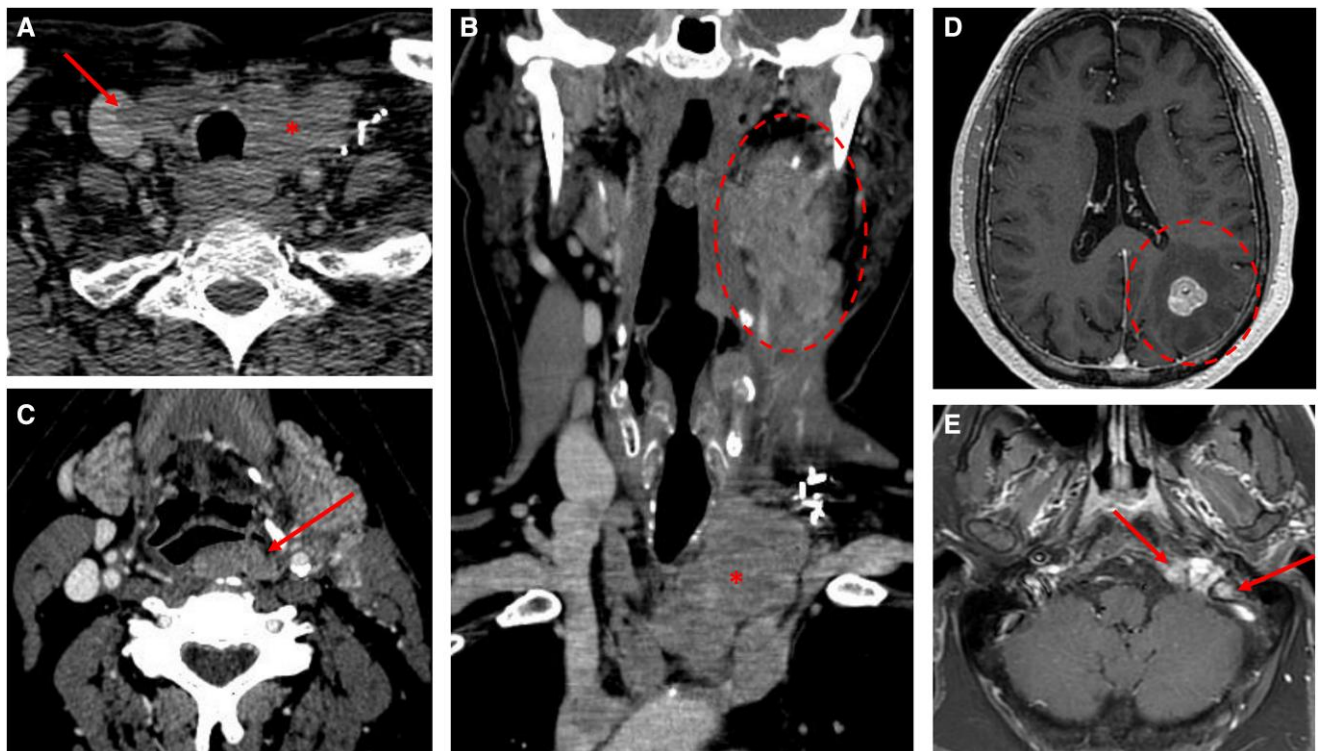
Contrast-enhanced A and C, axial and B, coronal computed tomography images of the neck at initial presentation to our institution (July 2021) demonstrating a lobular 3.4×6 cm mass in the left thyroid bed, extending inferiorly into the anterior mediastinum (A and B, *). There is focal invasion of the right internal jugular vein (A, arrow). Conglomerate left level 2 nodal metastases also seen measuring up to 5.5 cm in craniocaudal dimension (B, dotted circle), as well as a 2.3 cm left retropharyngeal lymphadenopathy causing mass effect on the left lateral aspect of the pharynx (C, arrow). Contrast-enhanced axial magnetic resonance images of D, the brain and E, skull base demonstrating a 1.8×1.6 cm enhancing cerebral metastasis of the left parietal lobe (D, dotted circle) with regional edema and mild mass effect. An enhancing osseous metastasis to the skull base centered on the left petrous temporal bone with involvement of the jugular tubercle and likely soft tissue extension to the jugular foramen (E, arrows) was also present.
